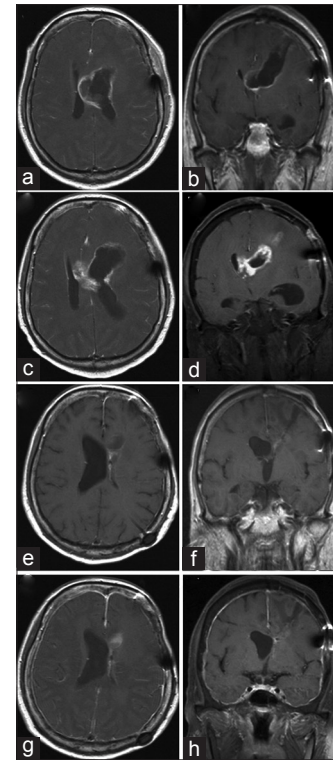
MRI of the brain from 1 week after surgery to 3 years and 4 months after diagnosis. Gadolinium-enhanced T1-weighted MRI. (a and b) 1 week after surgery ([a] axial section, [b] coronal section). (c and d) 2.5 months after diagnosis ([c] axial section, [d] coronal section). (e and f) Two years and 2 months after diagnosis ([e] axial section, [f] coronal section). (g and h) Three years and 4 months after diagnosis ([g] axial section, [h] coronal section). MRI – Magnetic resonance imaging
